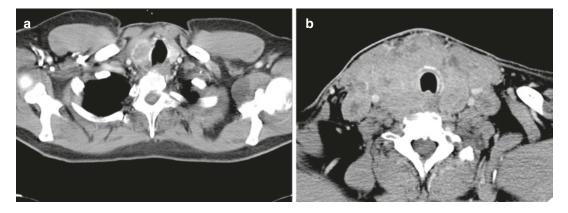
Neck MRI scans of patients with (a) Stage IVB (resectable) and (b) Stage IVB (unresectable) disease
